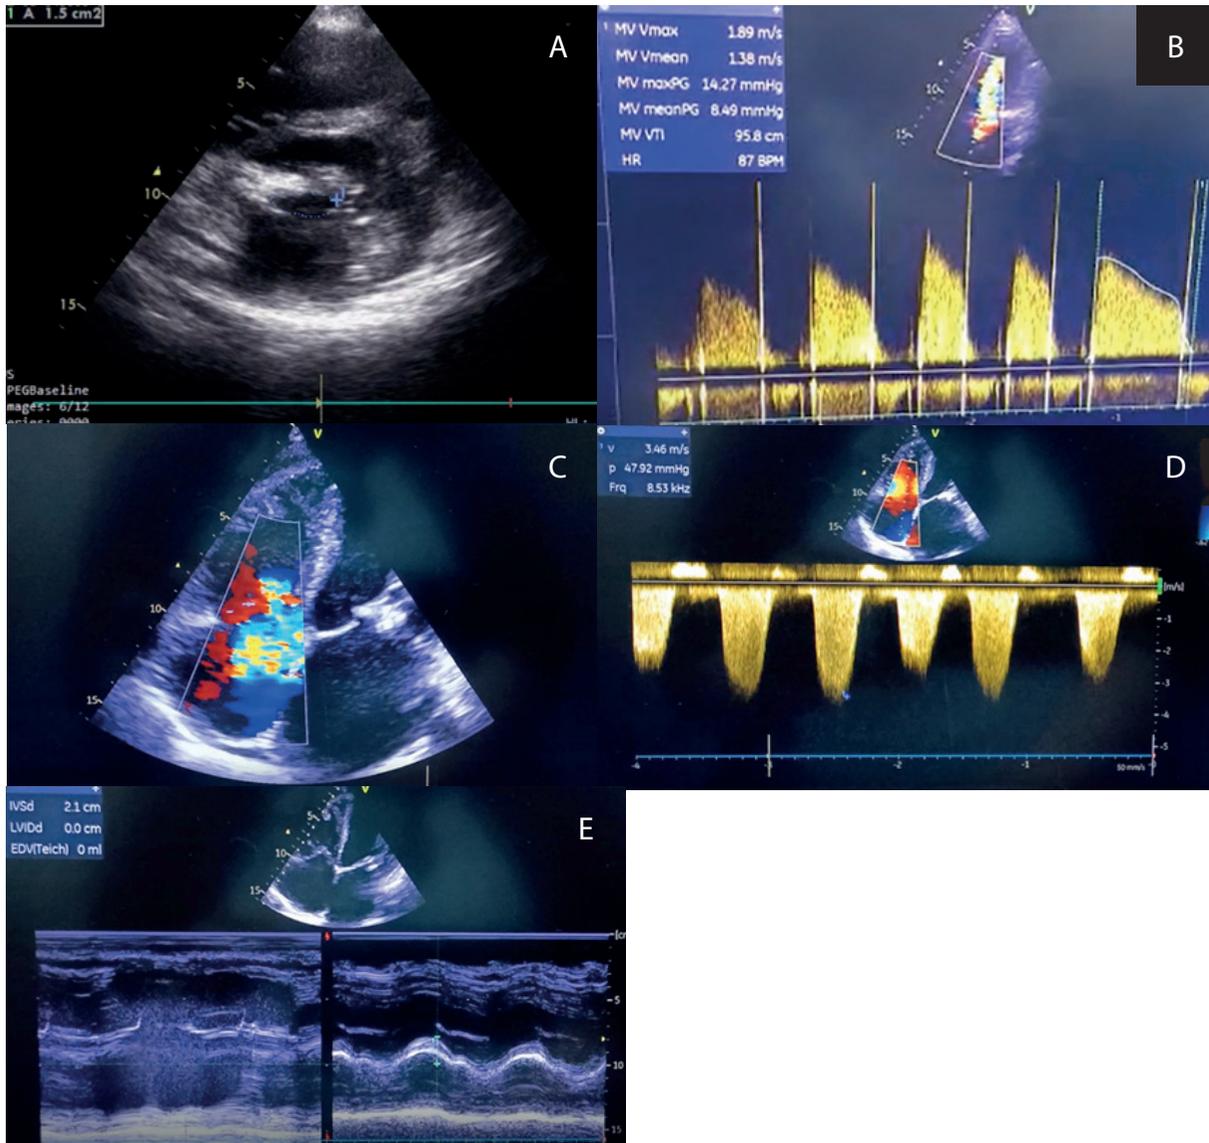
Baseline echocardiographic parameters. Panel A: Mitral valve area by planimetry. Panel B: Mitral valve gradient as assessed by mitral inflow velocity. Panel C: Tricuspid regurgitation. Panel D: Assessment of right ventricular systolic function. Panel E: Assessment of right ventricular function by tricuspid annular plane systolic excursion (TAPSE).
